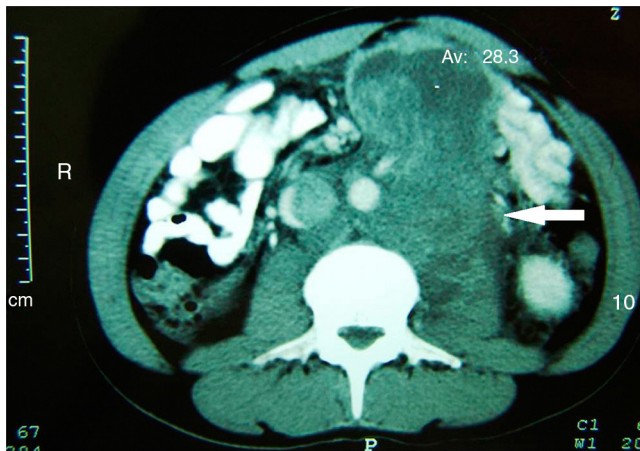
Computed tomography scan. A retroperitoneal tumor of 6 cm × 13 cm is observed.
